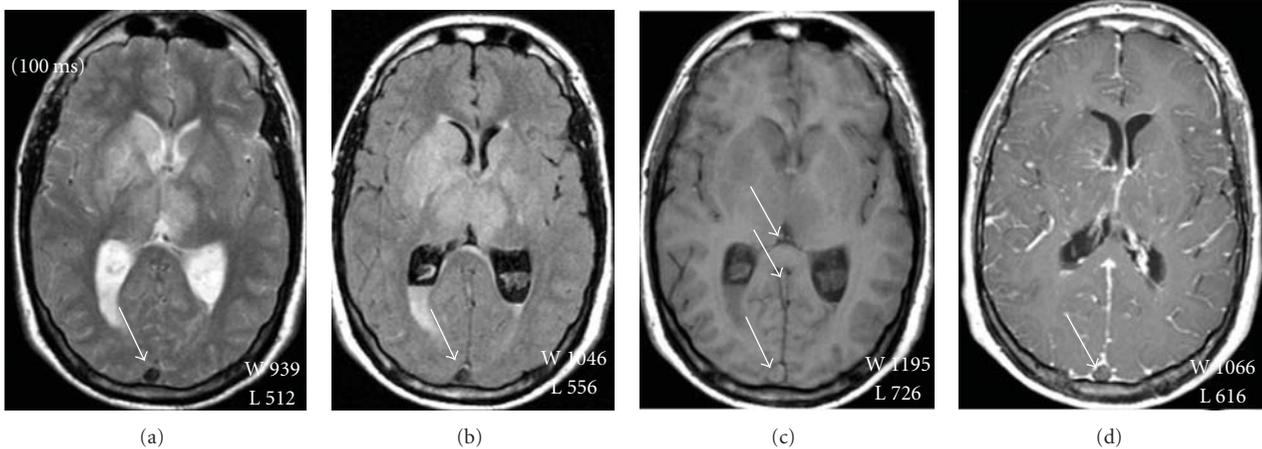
A 16-year-old female with progressively worsening headache, generalized seizures on the 4th day and coma on the 5th day. MRI exam was performed on the 5th day. MRI T2-weighted Turbo Spin Echo (a) and T2-weighted Fluid Attenuated Inversion Recovery images (b) show altered signal intensity involving bilaterally medial thalamus, lentiform nucleus, and caudate nucleus. Intraventricular bleeding is present and hemorrhagic infarct involving right frontoparietal junction (not shown) was also detected. Superior sagittal sinus and internal cerebral veins seem to have regular “flow void” signal (arrows), due to the dark signal of subacute thrombus. MRI T1-weighted images before (c) and after (d) administration of contrast agent better show occlusion of superior sagittal sinus, vein of Galen and internal cerebral veins (arrows). Visible advanced signs of venous stasis and the so-called “delta sign” (arrow) (d).
